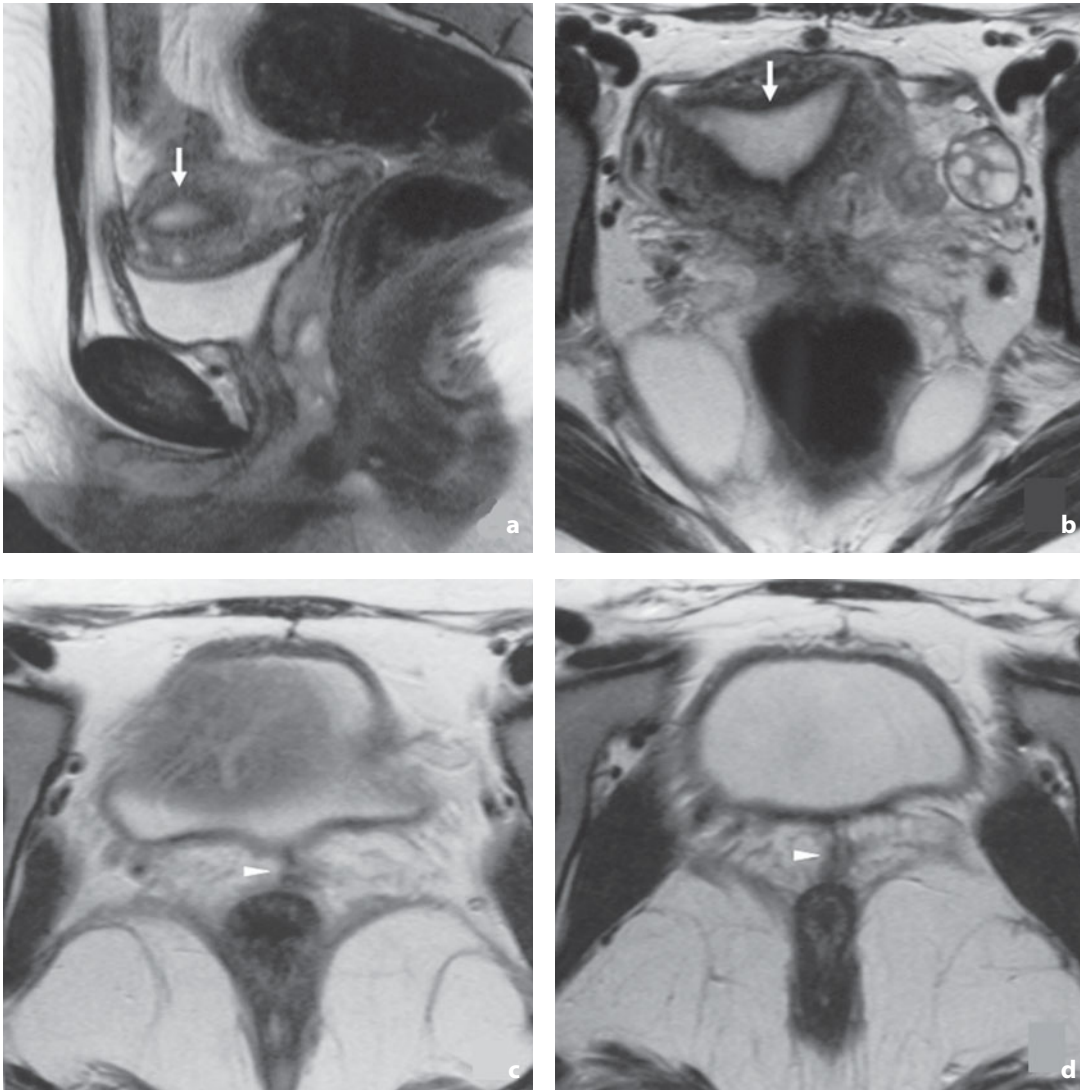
Vaginal atresia. T2-weighted MR scans in the sagittal (a) and axial (b-d) planes show the collection of fluid in the uterine cavity (*arrow*). The constricted vaginal tract appears as a hypointense tubular structure (*arrowhead*)
